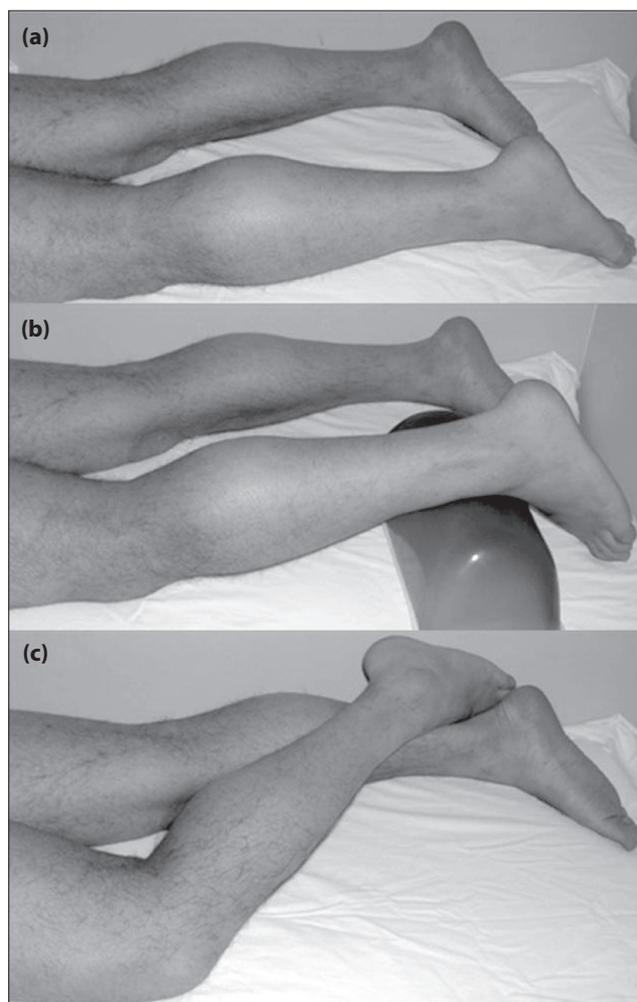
Three different positions of the left leg during ultrasound examination. (a) Patient in neutral position. (b) Patient with a roller under the foot. (c) Patient in “figure of four” position.
